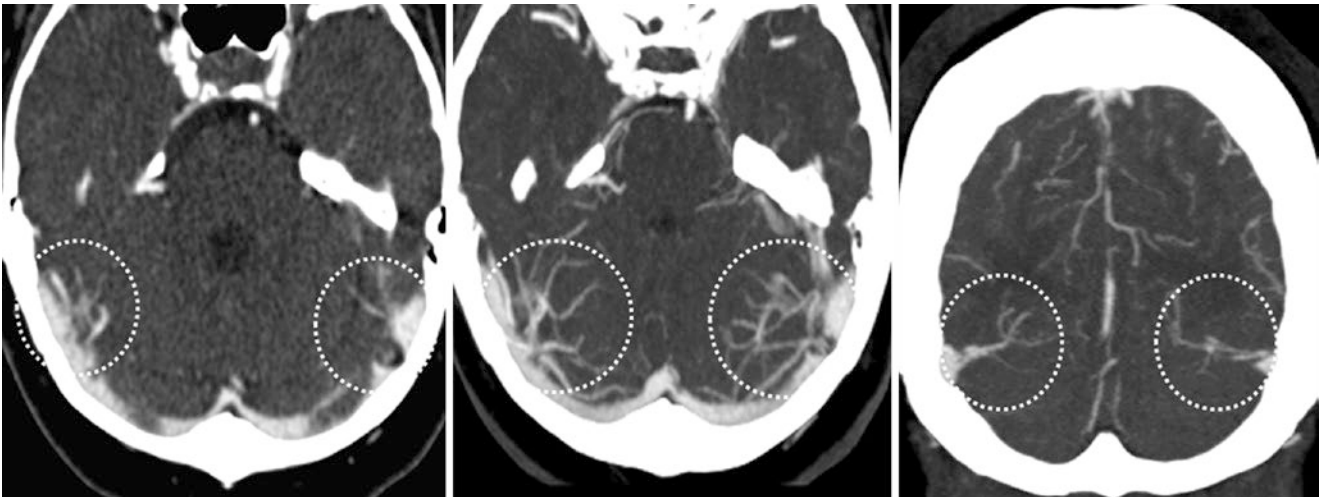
54-year-old with a right type I and a left type I or type II LTS (*dashed circles*) on axial thin (<1 mm) CTA images (*left*), which on thicker (15–20 mm) MPR images (*middle*) appear prominent but
